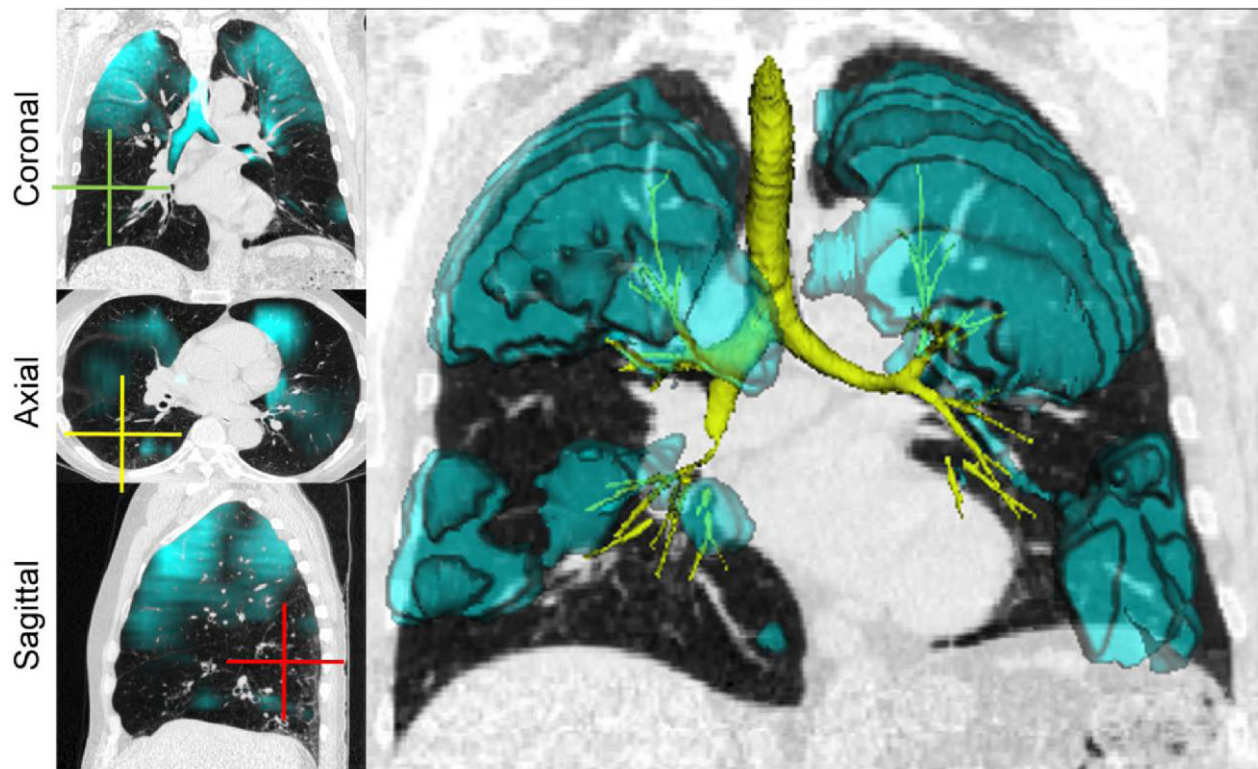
^3He MRI ventilation defects and CT represent an emphysema dominant phenotype in chronic obstructive pulmonary disease. Three-dimensional co-registration of ^3He static ventilation (shown in blue) and CT density mask (RA_{950} map shown in yellow) highlights the emphysematous regions and airway tree segmented in brown.
